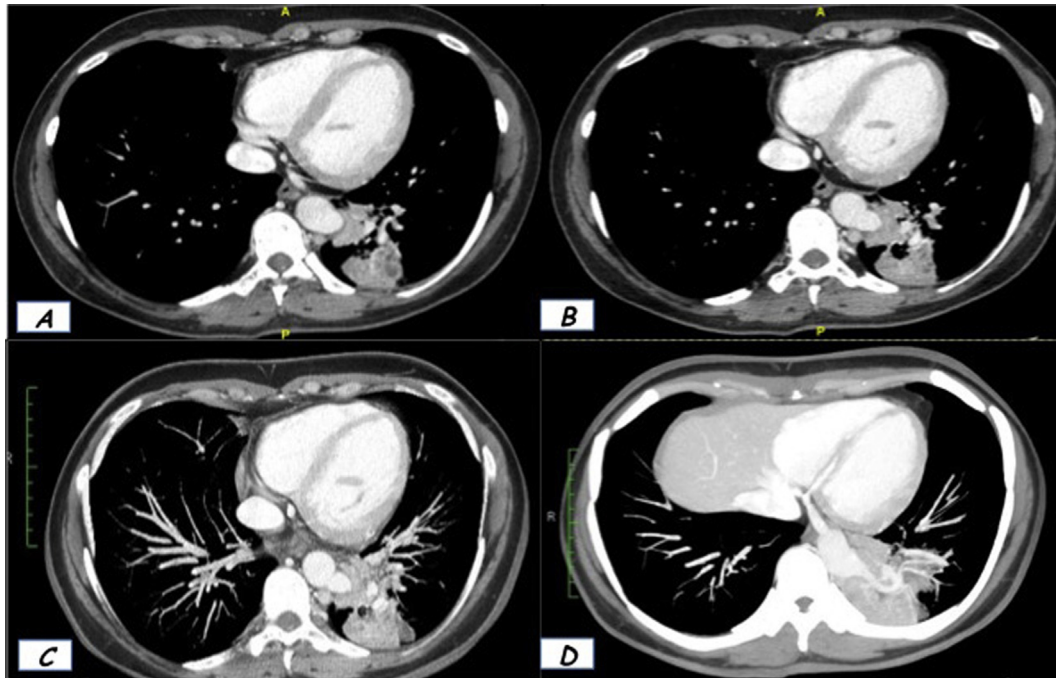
Contrast-enhanced lung CT scan report partial Pulmonary Sequestration which arterial supply arise from a supradiaphragmatic aortic diverticulum – axial view (A–B) and Maximum Intensity Projection (MIP) (C–D) view.
